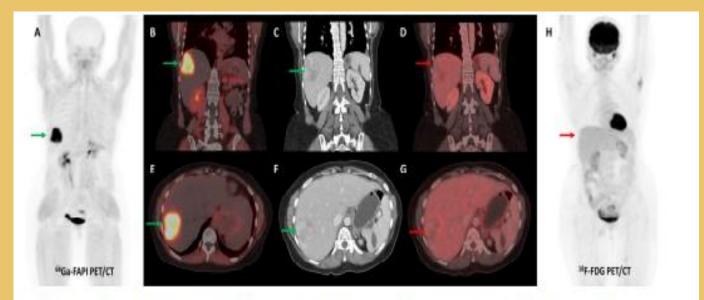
Forty-seven-year-old woman, a known case of ovarian carcinoma (clear cell type) postsurgery and adjuvant platin-based chemotherapy had rising serum CA-125 levels. She underwent [68Ga]Ga-FAPI-04 and FDG PET/CT for restaging, which revealed a heterogeneously enhancing lesion (~5.1 × 3.5 cm) in segment VII of the liver ((C,F)—green arrows) with intense FAPI uptake ((A,B,E)—green arrows) and no significant FDG uptake ((D,G,H)—red arrows) suggestive of liver metastasis.
